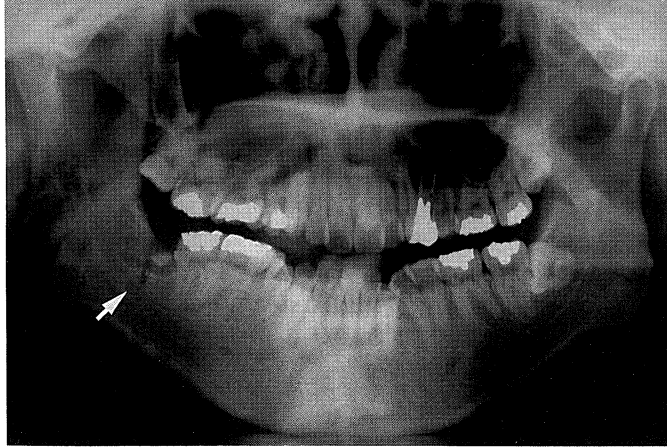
Panoramic radiograph revealed traumatic wound in the extraction cavity
